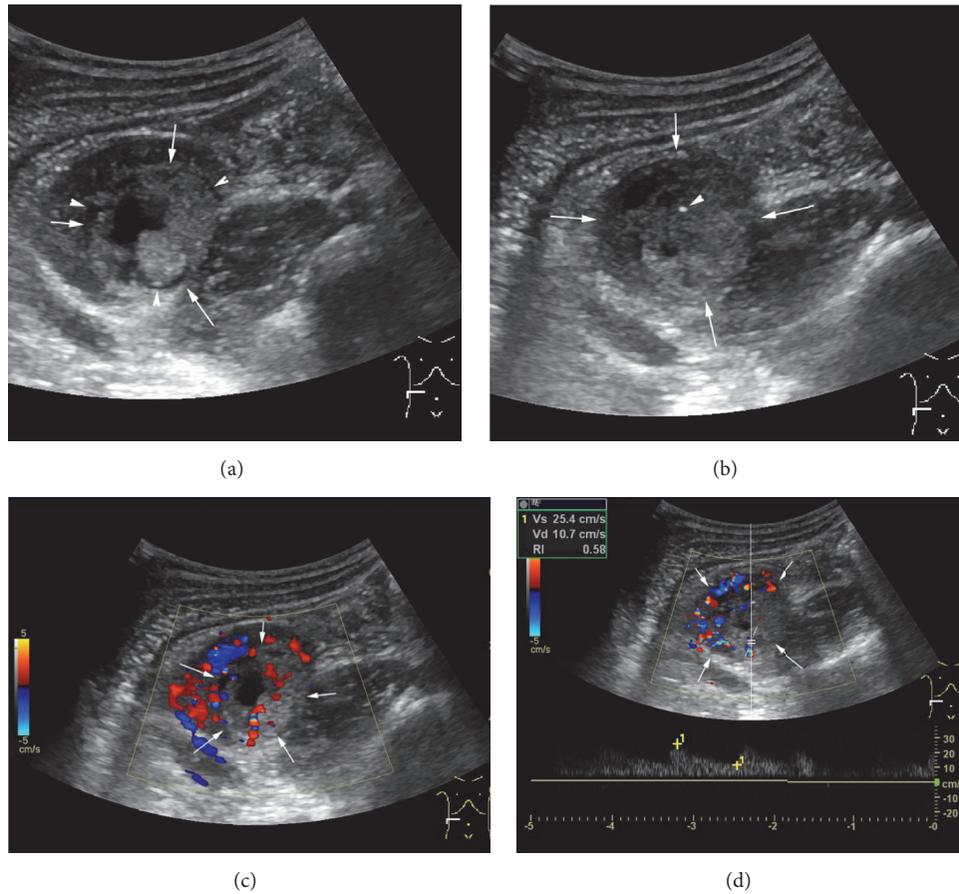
Case 1: male, 12 years old; a hyperechoic mixed mass was found in his right renal of lower part in the renal medulla. (a) Cyst-solid mass with size of 3.2×2.1 cm was found (arrow) and an annular hypoechoic halo sign surrounding the tumor was displayed (arrow head). (b) Spot calcification (arrow head) was found inside the tumor (arrow). (c) By CDFI mode, the solid component was found by multibranch threadiness color Doppler signal. (d) By PW mode, the solid component was detected by low blood flow resistance indexes (RI = 0.58).
